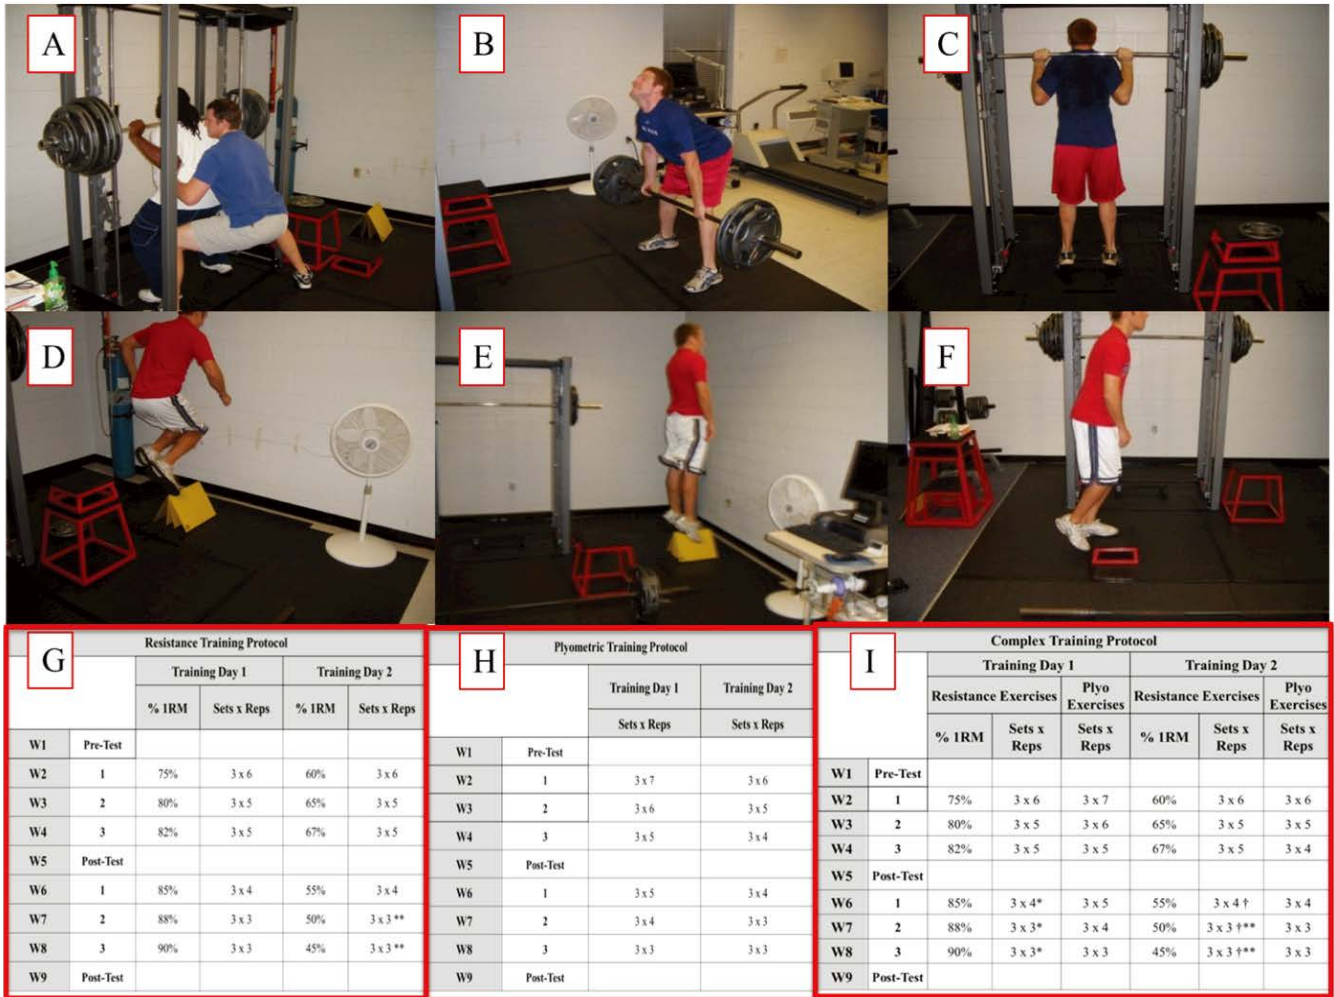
Figure 1A. back squat exercise; Figure 1B. SLDL exercise; Figure 1C. SCR exercise; Figure 1D. LJ exercise; Figure 1E. DJ exercise; Figure 1F. BXJ exercise; Figure 1G. RT protocol  = speed squats; Figure 1H. PT protocol; Figure 1I. CT protocol, † = 3 min rest between complex pairs,  = speed squats
